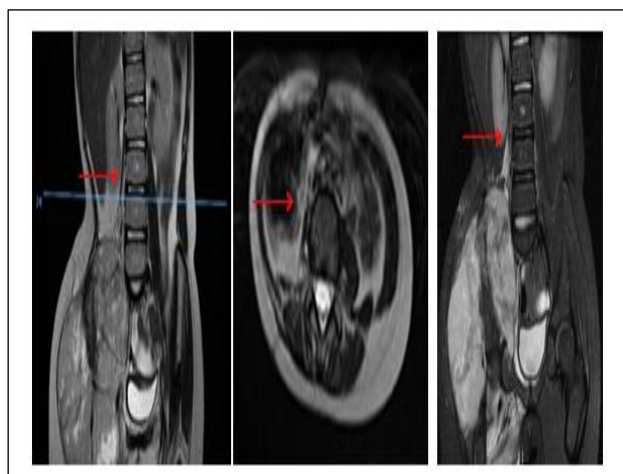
MRI of the lumbosacral spine, showing involvement of the right psoas major.
